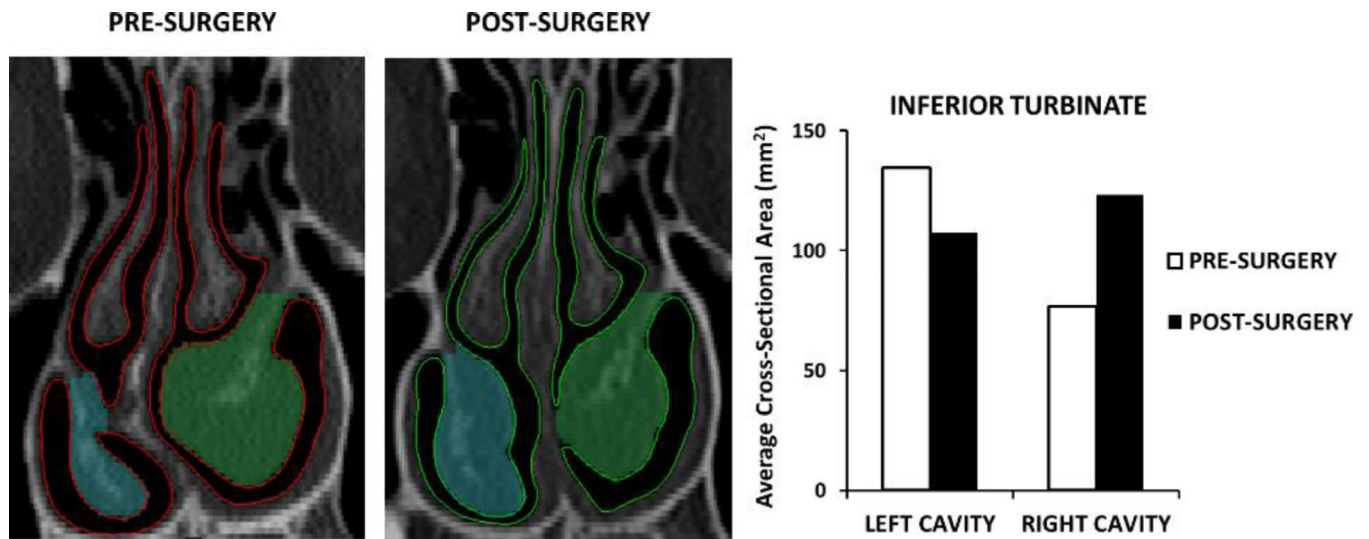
Reciprocal changes in mucosal engorgement associated with the nasal cycle between pre- and post-surgery CT scans in one NAO patient who underwent septoplasty. The regions marked in blue and green on the CT scans represent the inferior turbinate cross-sectional area at this coronal section. The cross-sectional area of the inferior turbinate was averaged over 5 uniformly-spaced coronal sections located at $0.5 \leq D \leq 0.9$ and used to select which patients exhibited nasal cycle changes between pre- and post-surgery CT scans.
